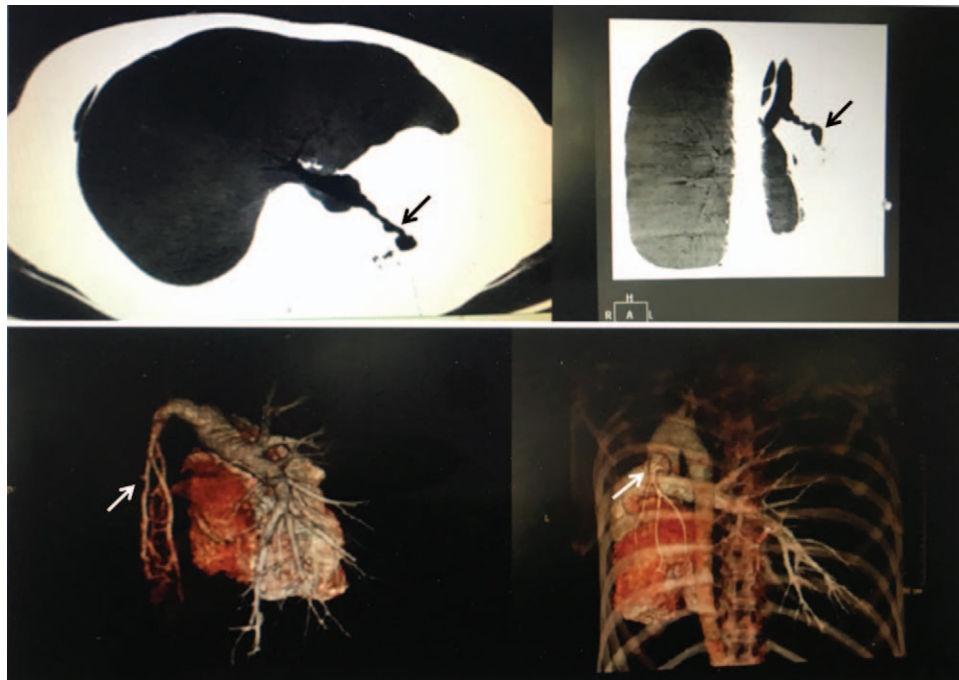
The 3D reconstruction (minimum intensity projection) with spiral computed tomography .Left main bronchus is thin and short and the lobar bronchi appeared reduced in caliber. 3D volume-rendered image. The left main pulmonary artery is obviously smaller than enlarged right main pulmonary artery and its hypertrophied and enlarged next several branching generations.
